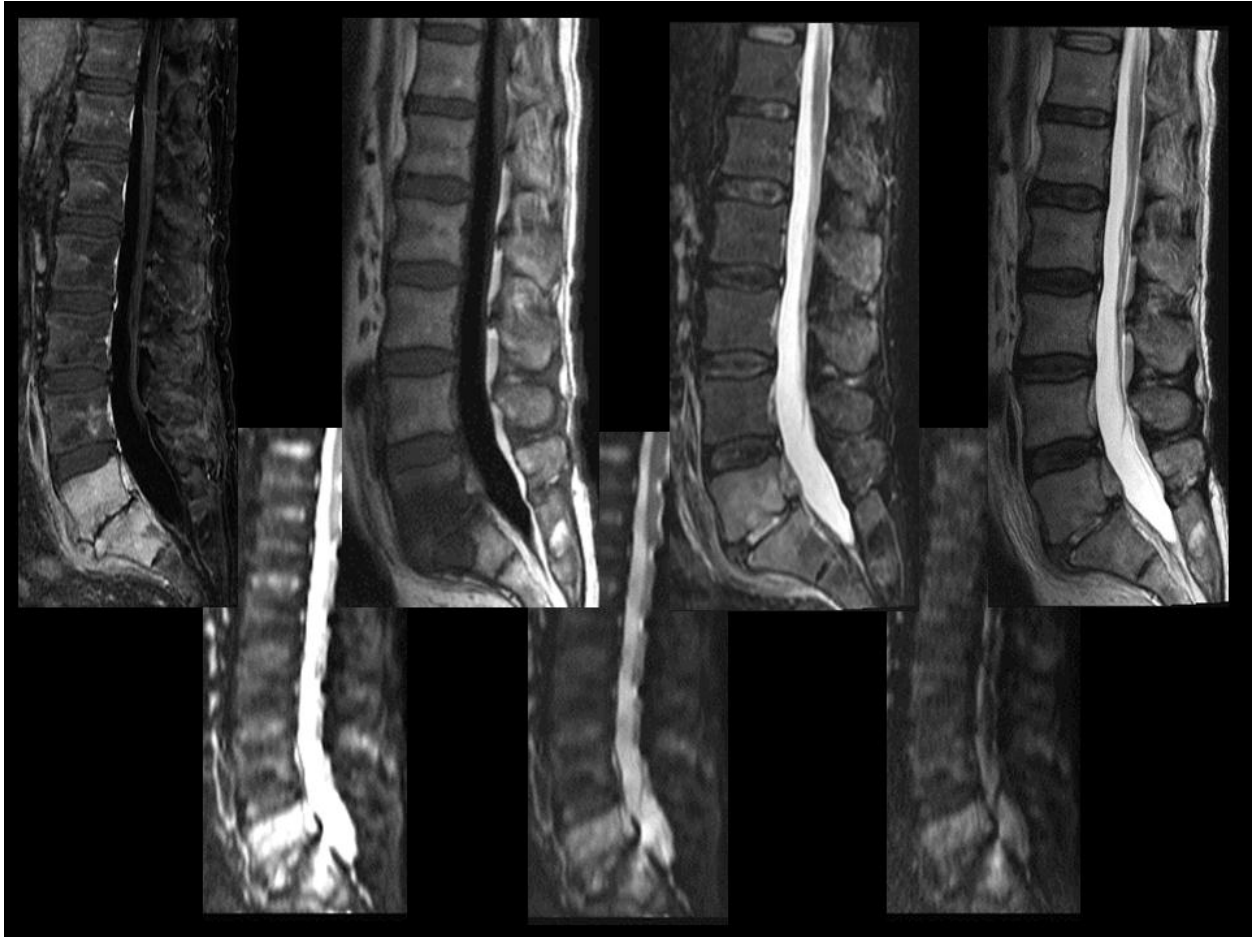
Osteomyelitis and discitis. Clockwise from upper left: Fat suppressed-contrast enhanced T1 FLAIR, T1 FLAIR, STIR, T2, DWI B=500,150,0. Note the diffuse increase in signal within the L5 and S1 vertebral bodies on DWI. The signal changes and enhancement on routine imaging sequence are characteristic of infection.
